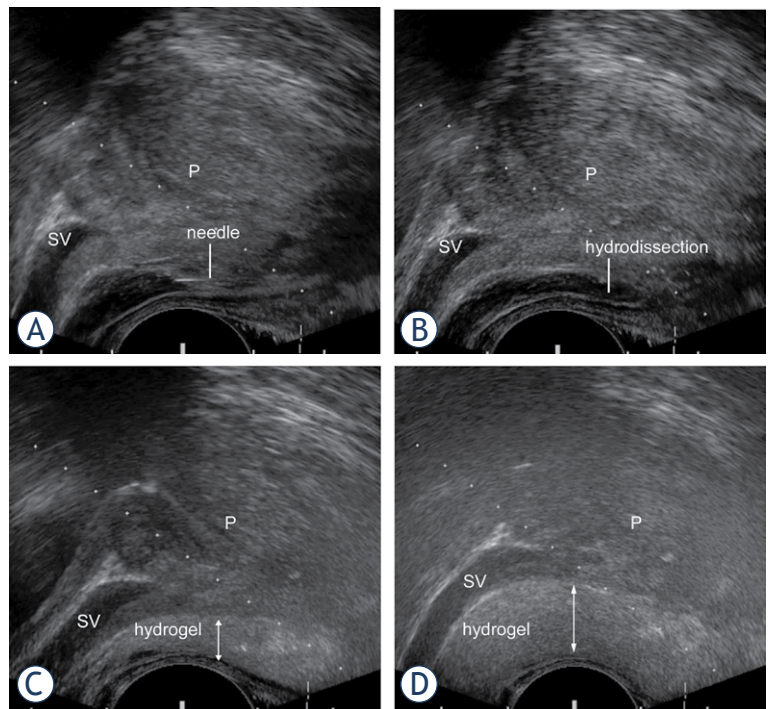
Hydrogel injection. Sagittal transrectal ultrasound images showing (A) the needle placed at the Denonvillier's fascia at the start of hydrodissection, after complete hydrodissection (B), at the start (C) and after successful hydrogel injection (D). Air contamination after hydrogel injection worsens visibility (D).
